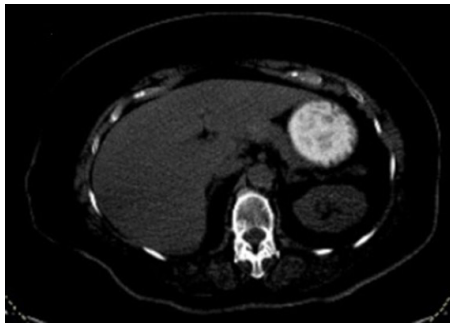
PET-CT scan; CT shows a mild hyperdense area in the pancreatic body barely distinguishable from the intact pancreas; a PET-CT image and fusion image show a 32 x 26 x 28 mm FDG avid mass (SUV_{max} : 30) localized in the pancreatic body and abutting the inferior surface of the liver. PET-CT, positron emission tomography-computed tomography; FDG, fluorodeoxyglucose.
